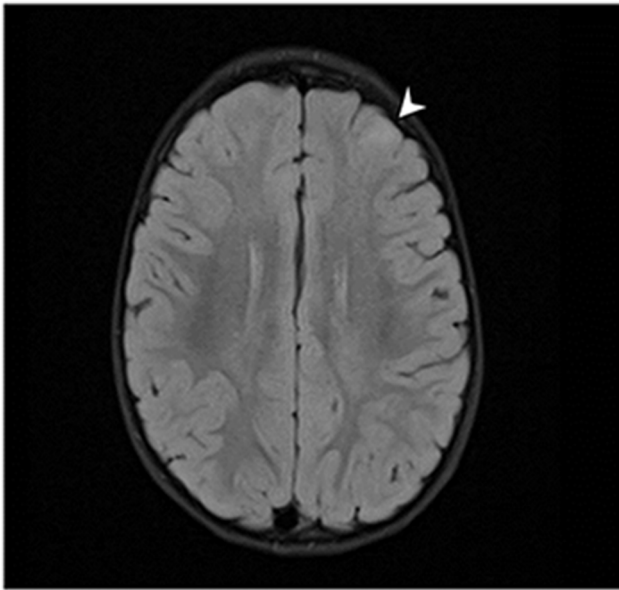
Axial T2 fluid-attenuated inversion recovery (FLAIR) image showed subcortical frontal tuber (white arrow)
